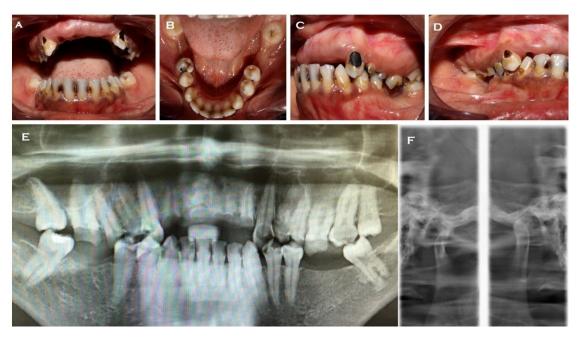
(A) Crowns of maxillary anteriors missing (B) Mandibular arch with bilateral missing first and second molars (C) Maximum intercuspation position showing relation of maxillary and mandibular teeth (D) Right lateral side showing the level of occlusal plane (E) Orthopantomograph showing the status of dentition (F) Orthopantomograph of temporomandibular joint
